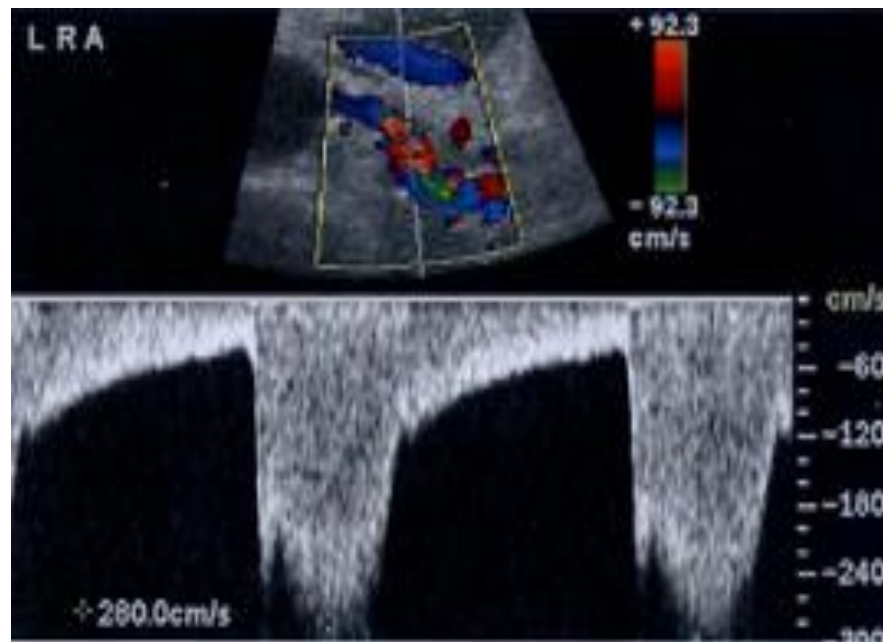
A pulsed Doppler waveform at a stenotic region showing elevated peak systolic velocity of 280cm/ sec.
